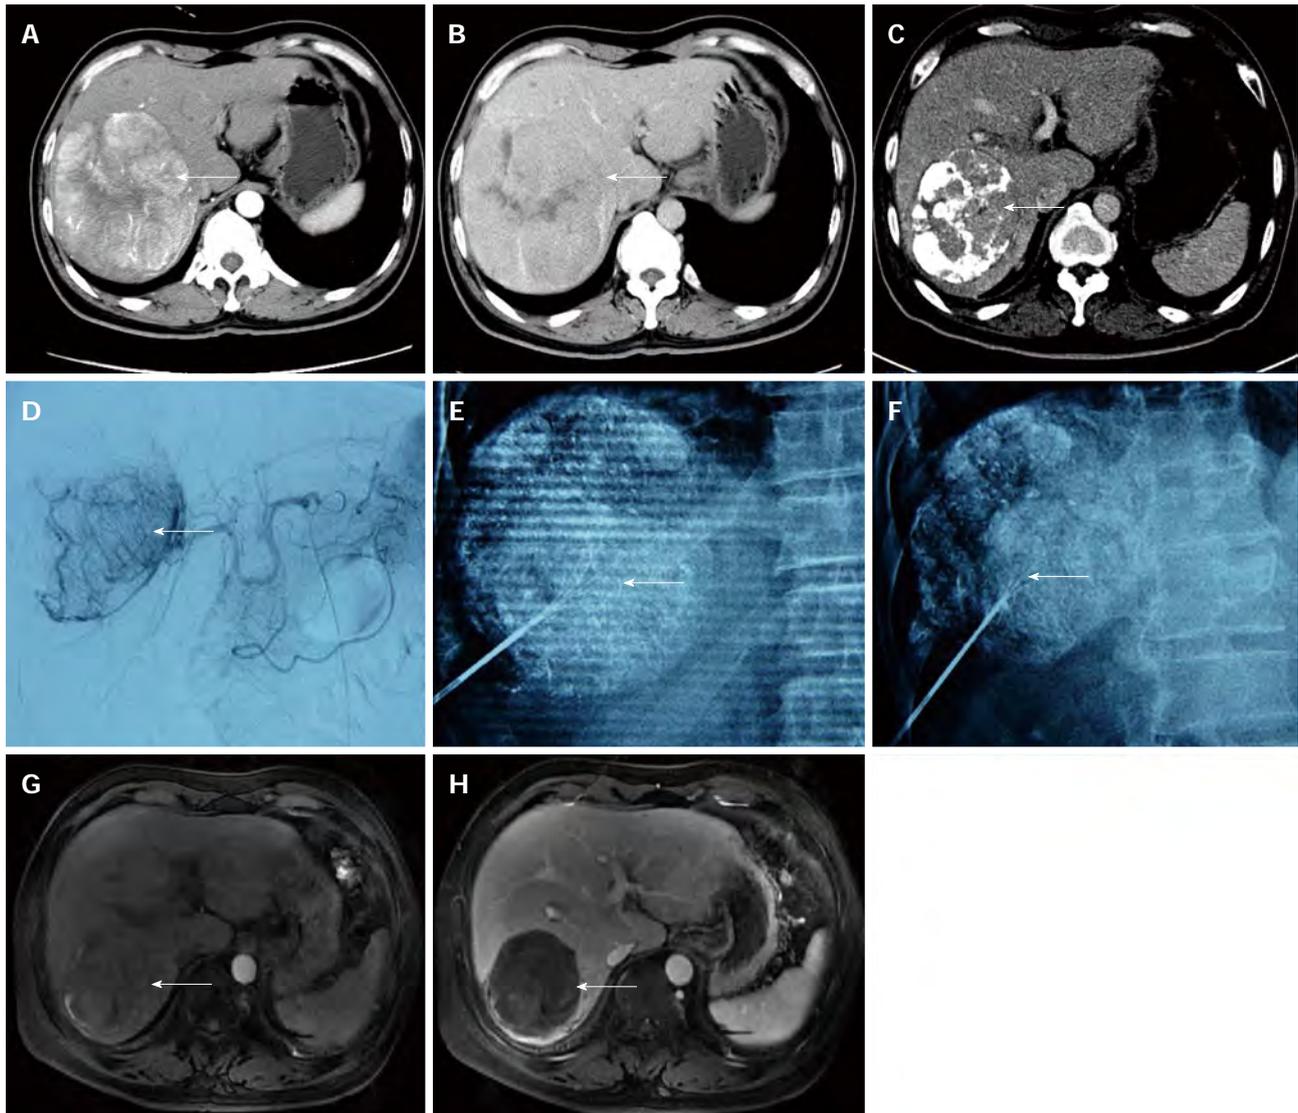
A male patient aged 53 years with a large lesion in the right lobe of the liver. A residual lesion was found after three cycles of transcatheter arterial chemoembolisation (TACE). TACE combined with radiofrequency ablation (RFA) was performed under the guidance of digital subtraction angiography-computed tomography. A, B: A large hypervascular hepatocellular carcinomas was observed in the right lobe (arrow); C, D: A residual lesion around the lipiodol deposit was still visible after three cycles of TACE (arrow); E, F: The lesion was successfully labelled after TACE. A multipolar needle was opened and rotated 70° to the left (E) and right (F) sides to verify whether the RF needle was in the center of the residual lesion (arrow); G, H: The large lesion was well controlled, and no recurrence was observed by magnetic resonance imaging during 13 mo follow-up after combination therapy (arrow).
